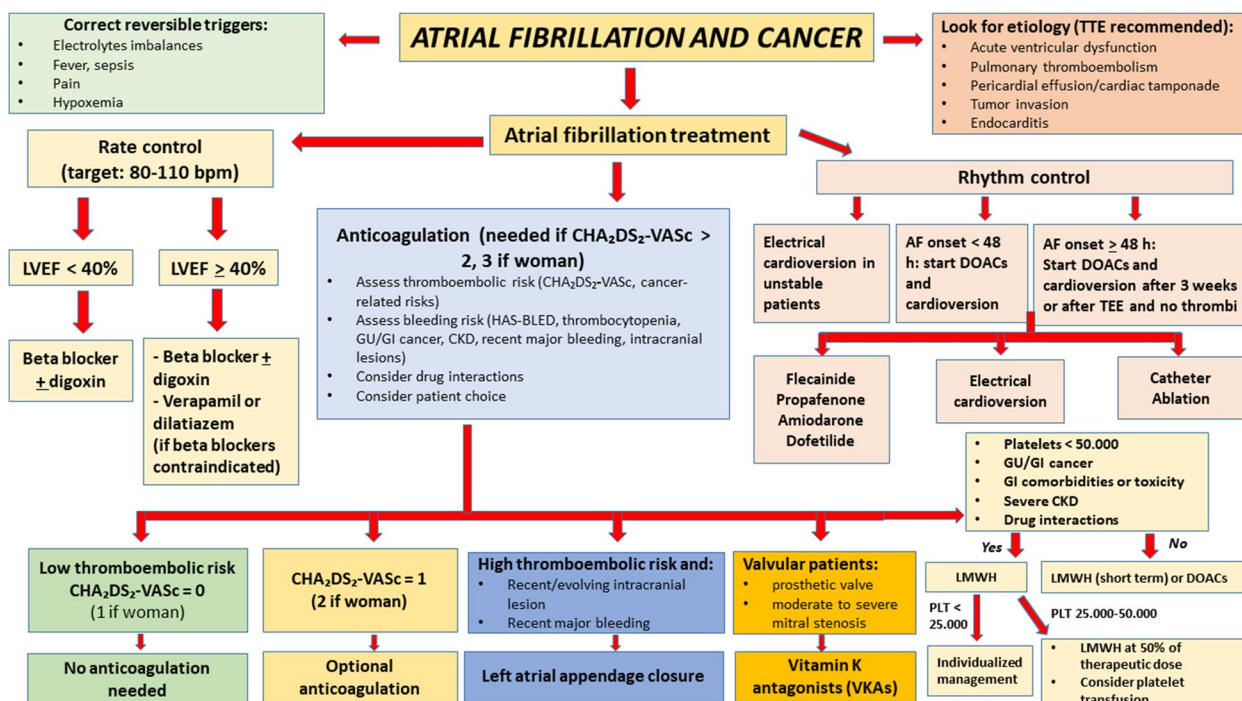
Management of atrial fibrillation in cancer patients. AF atrial fibrillation, CHA₂DS₂VASc score (congestive heart failure/LV dysfunction, hypertension, age > 75, diabetes mellitus, stroke/TIA, vascular disease, age 65–74, sex), CKD chronic kidney disease, DOAC direct oral anticoagulant, GI gastrointestinal, GU genitourinary, HAS-BLED score (hypertension, abnormal liver or renal function, stroke, bleeding, la-bile international normalized ratio, INR, elderly with age > 65, drugs or alcohol); HF heart failure, INR international normalized ratio, LMWH, low molecular-weight heparin, LV left ventricular, LVEF left ventricular ejection fraction, PLT platelets, TEE transthoracic echocardiography, TIA transient ischemic attack, TTE, transthoracic echocardiography, VKAs vitamin K antagonists
